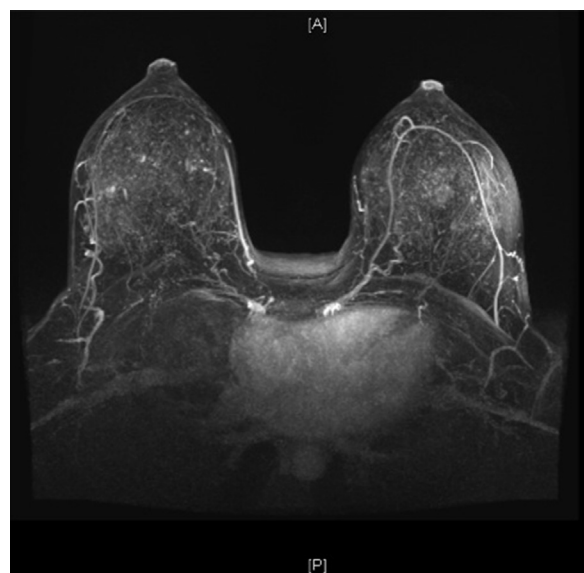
Single cut of a representative MRI (MIP) image of both breasts. This patient has a multi-zone blood supply to the NAC, which was classified as Type Ib, IIa, III on the left and Type Ib, IIa on the right, based on multiple cuts of the MRI images including MIPs, coronal, axial and sagittal.
